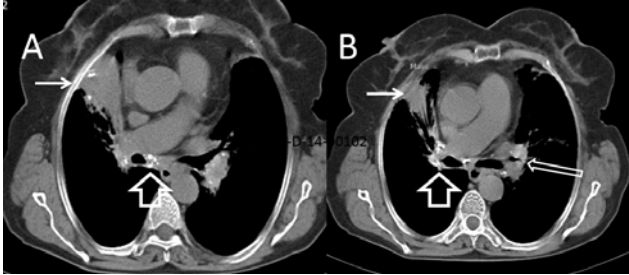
Computed tomography of a subject with diffuse anthracofibrosis; A: Mediastinal calcification (wide non-filled arrow) and mass lesion in parenchyma (narrow filled arrow), B: Bronchial narrowing (narrow non-filled arrow) and mass lesion in parenchyma (narrow filled arrow).
